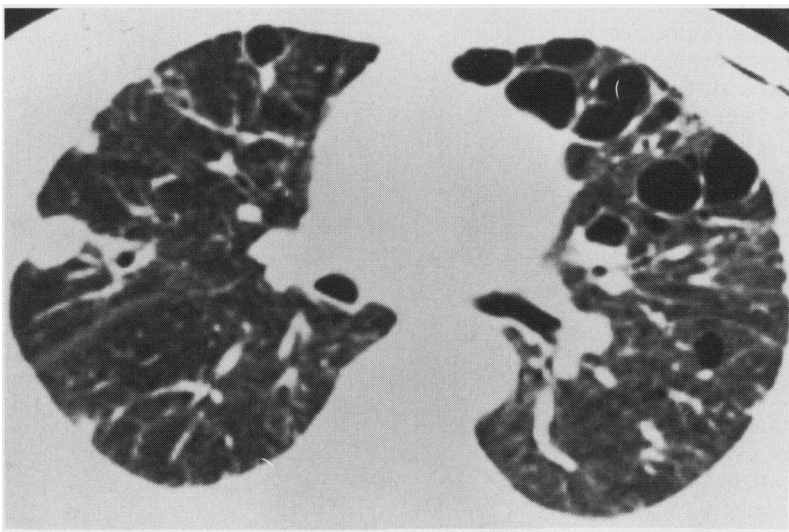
Computed tomography of the chest four weeks after independent lung ventilation showing the remaining pneumatoceles.
